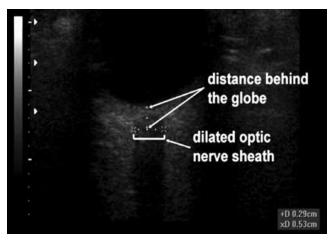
Sonographic view of the globe and the optic nerve. (Source: www.lifeinthe fastlane.com/ophthalmology-befuddler-015)
